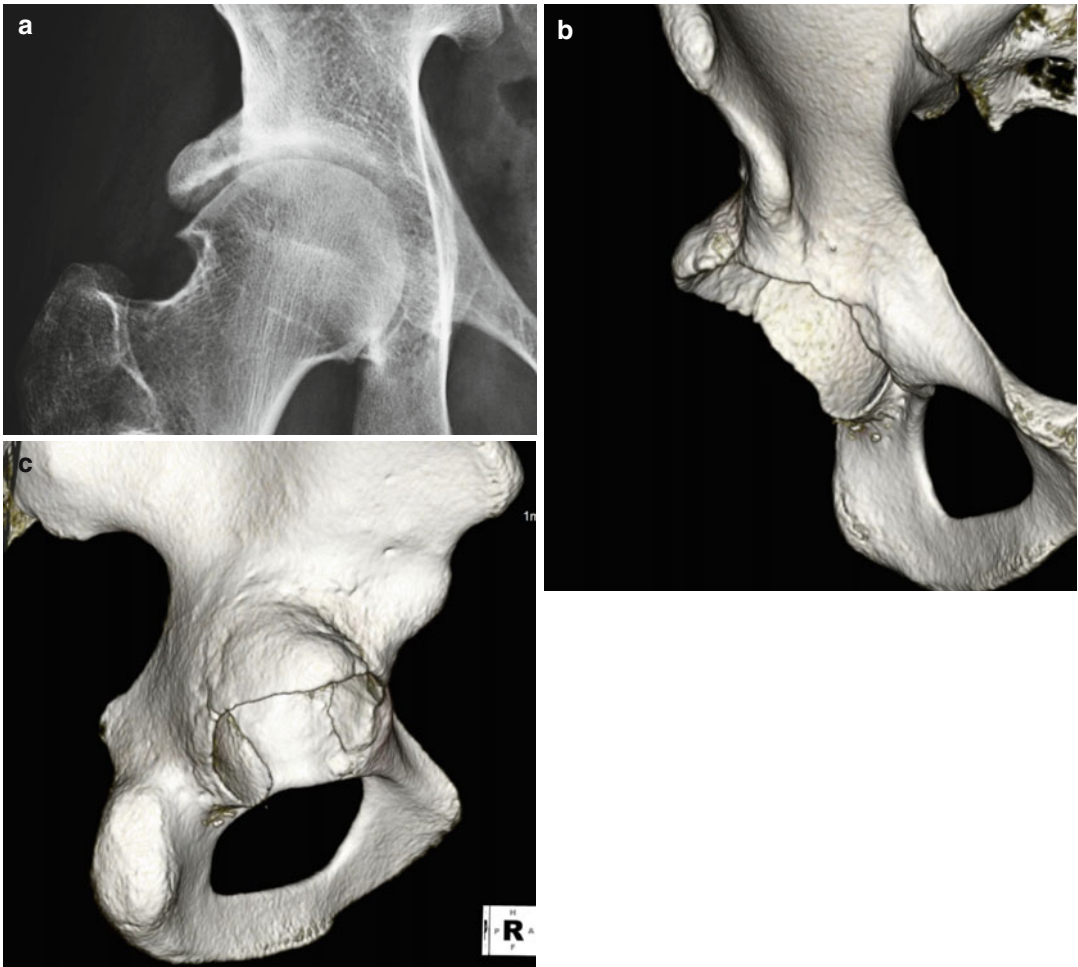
19-year-old male with isolated lateral acetabular rim overcoverage seen on plain AP radiograph (a), and with 3D CT reconstruction on AP (b) and lateral (c) views
